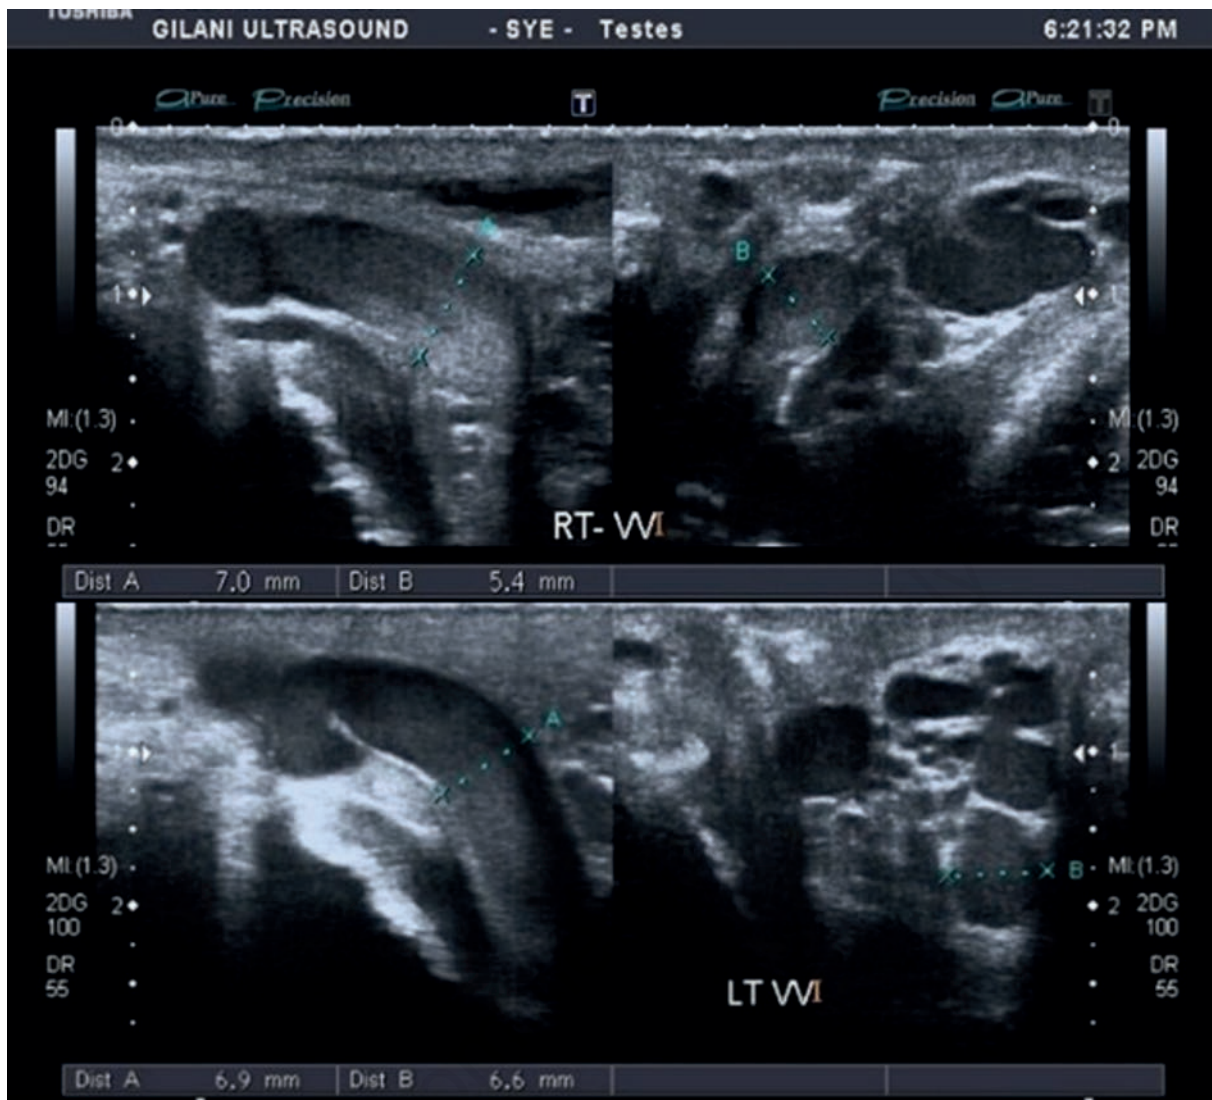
Ultrasound images of a 26-year-old obese patient with a right-sided varicocele measuring 7.0 mm and 5.4 mm; and a left-sided varicocele measuring 6.9 mm and 6.6 mm.
